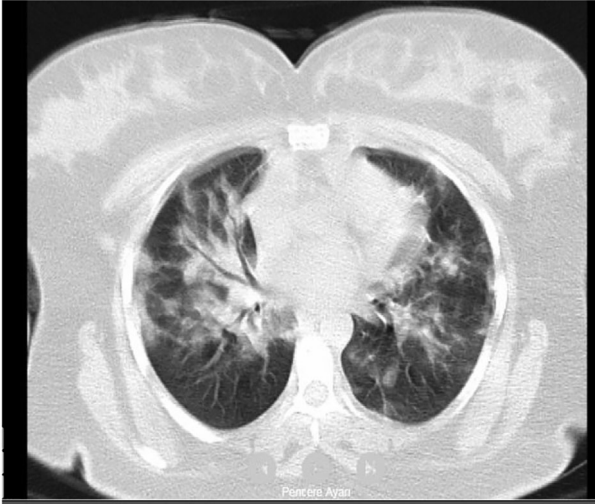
Case 2's CT image indices common opacities after cesarean section
